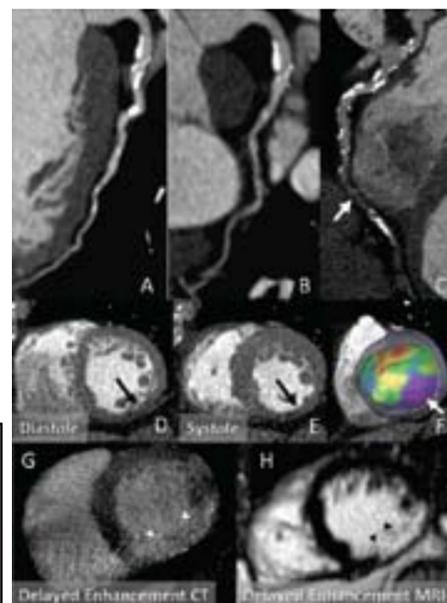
Curved multiplanar reformats of the left anterior descending (A), circumflex (B) and right (C) coronary arteries of the same patient. Coronary CT angiography reveals distal right coronary artery occlusion (arrow in C). Functional analysis shows inferolateral akinesis (arrows in D, E, and F). First-pass stress perfusion CT (G) demonstrates inferior and inferoseptal perfusion defect (arrows), which was confirmed on perfusion MRI. This perfusion defect corresponds to known chronic infarction, as confirmed by delayed enhancement CT (G) and MRI (H) (arrowheads)
